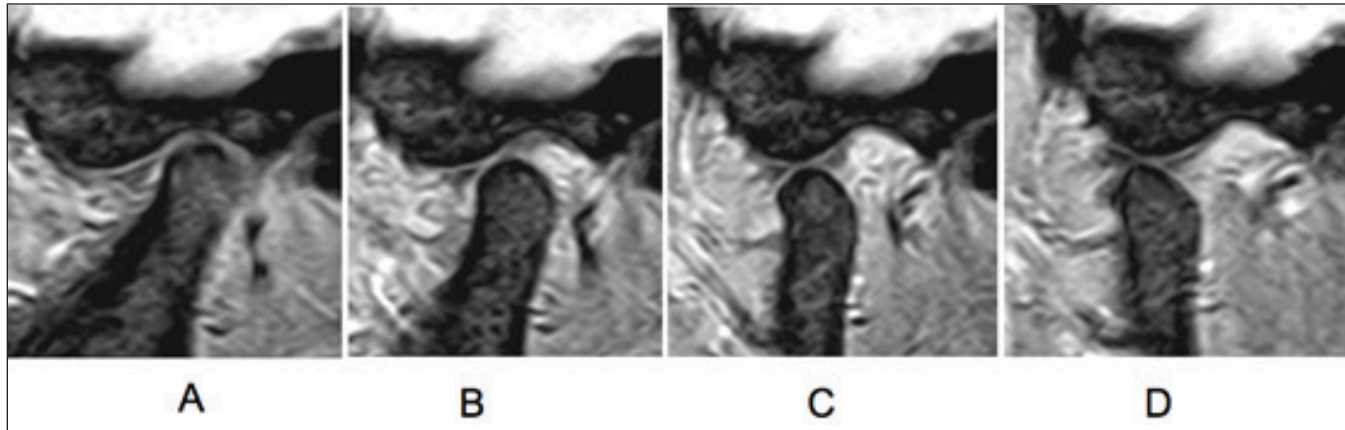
Sagittal MRI of a TMJ classified as “Disk displacement with reduction”. The sequence shows a TMJ at close mouth (A), 10 mm (B), 20mm (C) and 40mm. of inter-incisal distance (D). In this case, the displaced disk has been recaptured at 10mm of inter-incisal opening. This image belongs to a Female 14 years old patient
